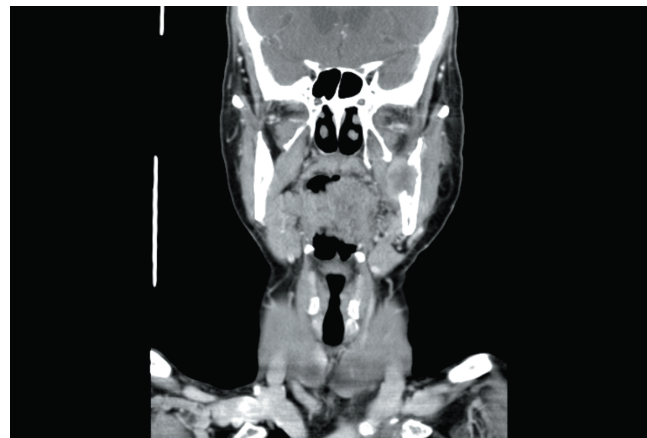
CT coronal image from the mandibular metastasis on the left ascending ramus at the time of the biopsy.
